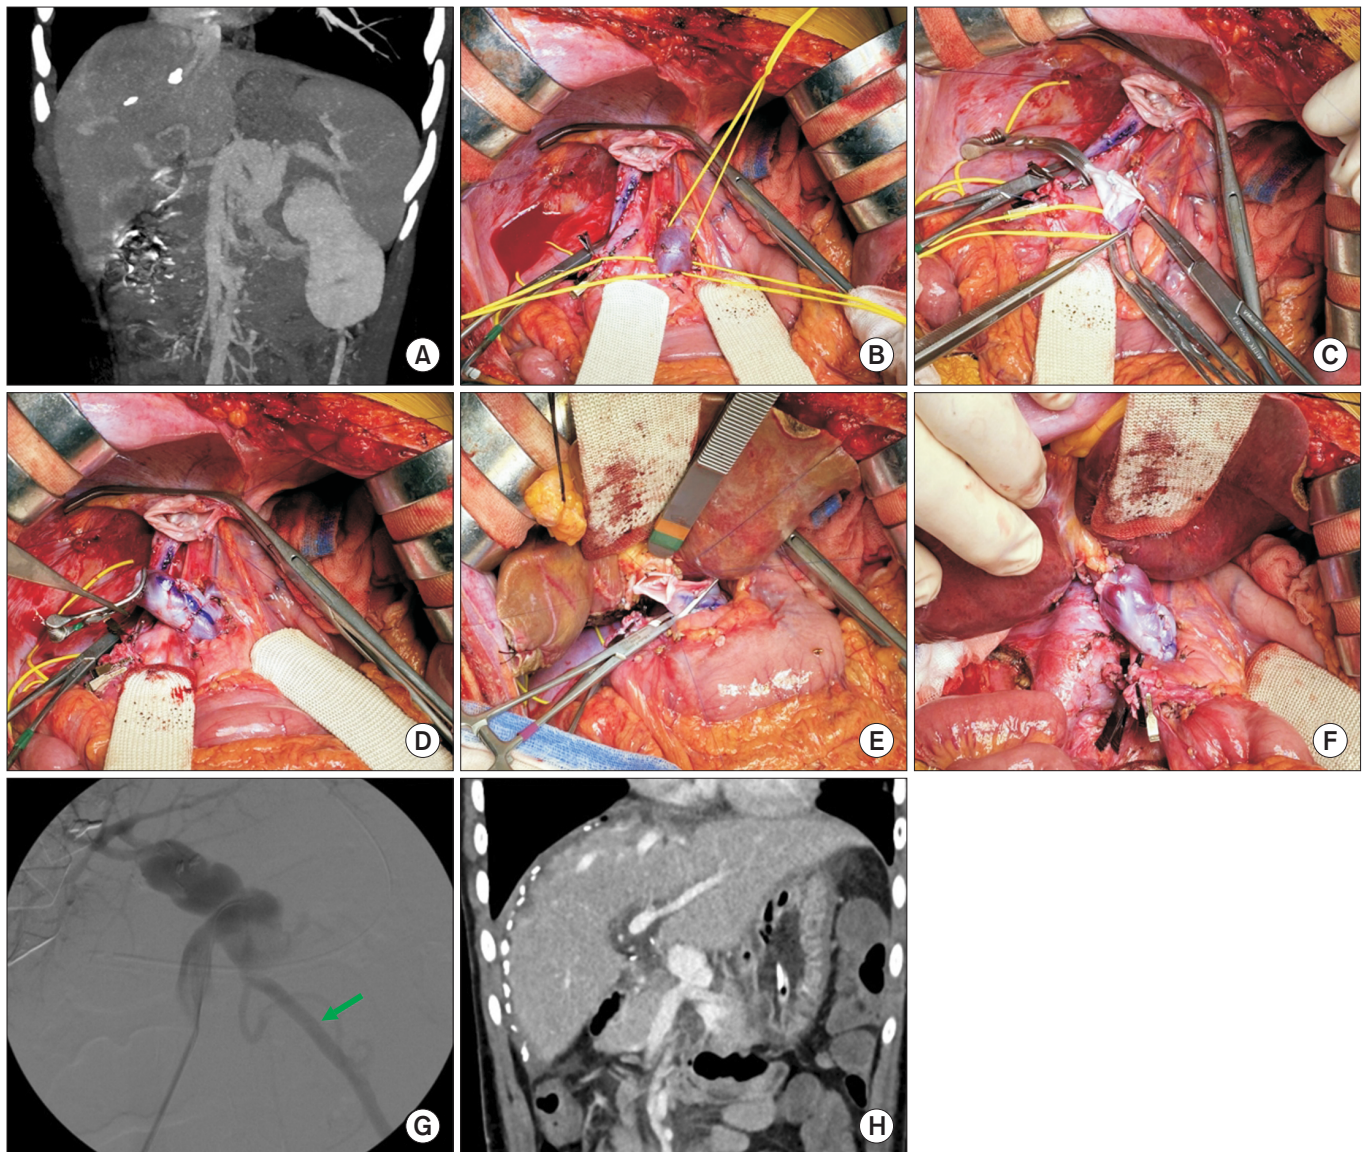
Image summary of living donor liver transplantation case 4. (A) Pretransplant computed tomography (CT) showed complete absence of the portal vein. (B) The confluence of the mesenteric and splenic veins was meticulously dissected, with branches isolated. (C) A 1.5-cm longitudinal incision was made at the confluence. (D) An iliac vein conduit was anastomosed to the confluence in an end-to-side fashion. (E) The iliac vein conduit was then anastomosed to the graft portal vein. (F) Portal flow increased after ligation of the splenorenal shunt. (G) Intraoperative direct portography showed good portal flow through the conduit and identified a collateral vein to be ligated (arrow). (H) Posttransplant CT obtained 4 days later showed the iliac vein conduit from the mesenteric-splenic vein junction functioning as the main portal trunk. Reproduced from Namgoong et al. *Ann Hepatobiliary Pancreat Surg* 2021;25:401–7. [9]
